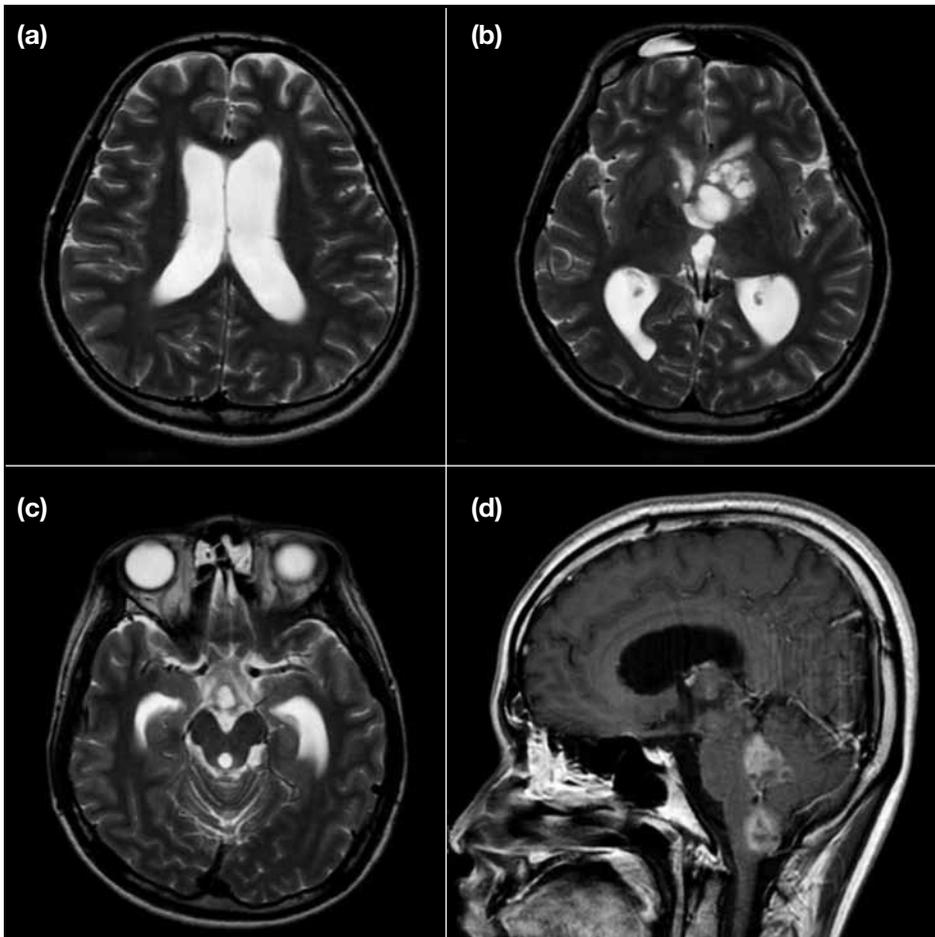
Case 4. 23-year-old male patient. Left basal ganglia germinoma with cerebrospinal fluid metastases in the fourth ventricle and cisterna magna causing obstructive hydrocephalus. (a to c) Axial T2-weighted and (d) sagittal post-contrast T1-weighted magnetic resonance images.
